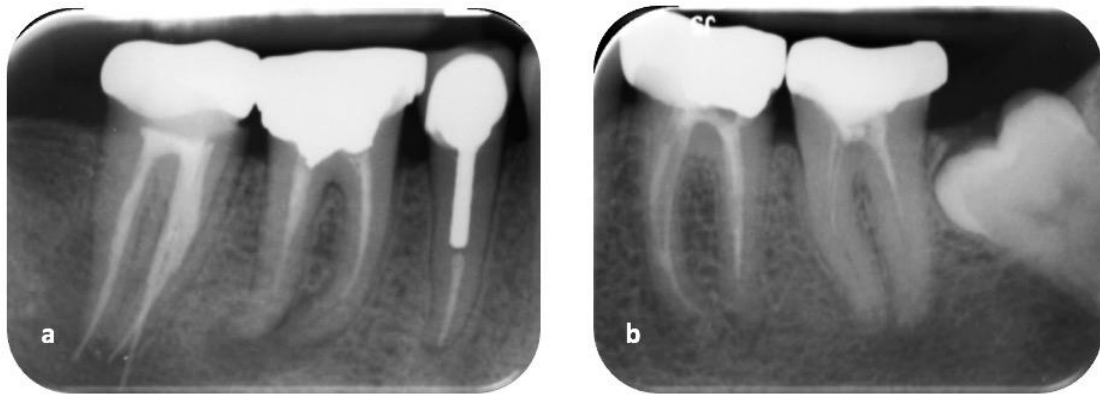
Pre-operative PA radiographs of teeth 36, 37, 45, 46 and 47
